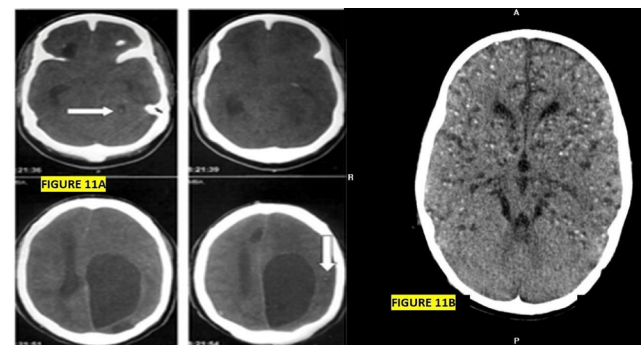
(A) Axial view of CT scan of the brain shows giant occipital lobe cysticercus and other cysticercus in the vesicular stage. This patient presented persistent headache, recurrent generalised motor ES, visual hallucinations, dysnomia, dyslexia, and palinopsia. Occipital lobe syndrome due to giant intraparenchymal NCC; (B) Axial view of CT scan of the brain shows massive NCC in the anterior circulation territory, sparing the vertebra-basilar territory
